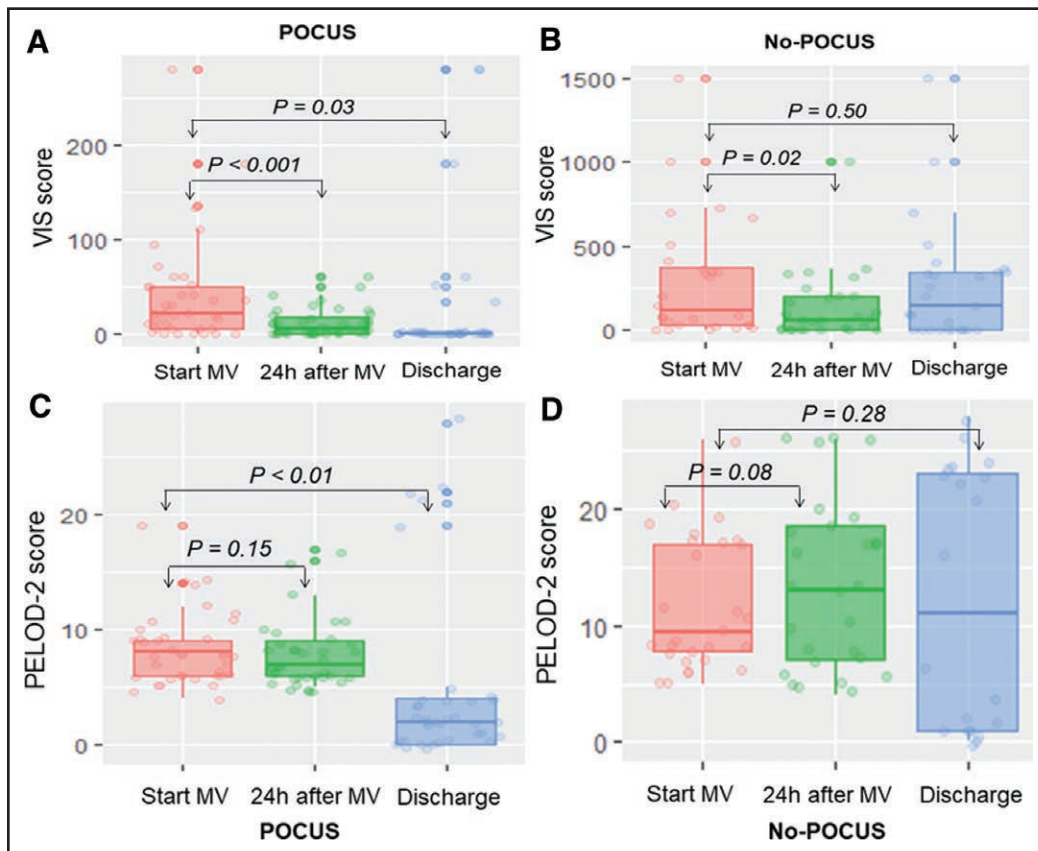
Serial-paired *t* tests in vasoactive-inotropic score (VIS) and pediatric logistic organ dysfunction (PELOD-2) score at various timepoints: at the initiation of mechanical ventilation (MV), 24 hours after MV plus fluid resuscitation, and at PICU discharge. In particular, the point-of-care ultrasound (POCUS) cohort showed significant improvements in VIS (A) and PELOD-2 (C) scores at 24 hours post-MV and at PICU discharge compared with baseline levels (at MV initiation). In contrast, the comparable no-POCUS group experienced deterioration in both the VIS (B) and PELOD-2 (D) scores at PICU discharge compared with baseline levels.
